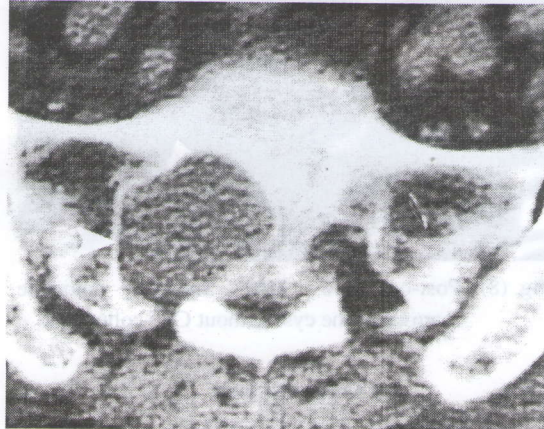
CT scan of the sacrum showed enlargement of the neural foramina.
